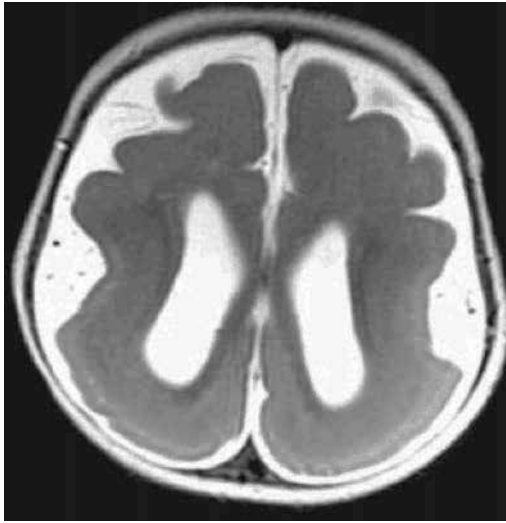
MRI brain axial T2-weighted image shows lissencephaly agyria and smooth brain. Especially posteriorly in a patient with LIS1 mutation.
